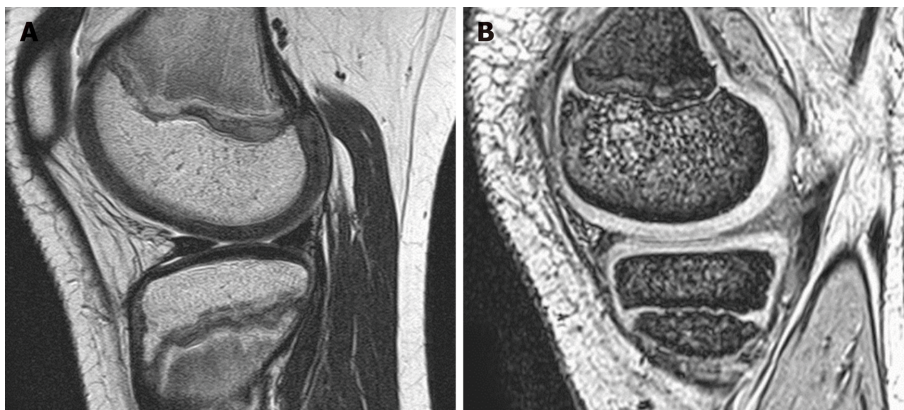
Magnetic resonance imaging scan of the knee during the hospitalization. T2-weighted image. A: Mildly increased signal intensity in the medial meniscus of right knee; B: No abnormal signal intensity.
